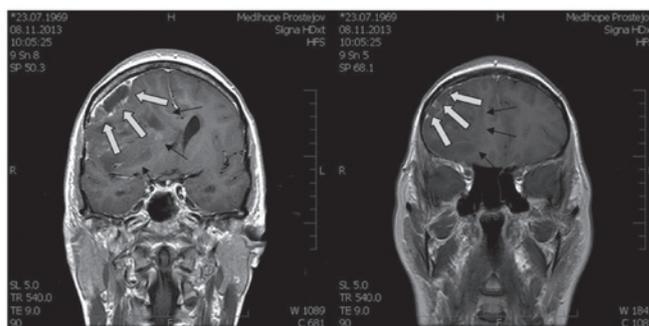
Preoperative magnetic resonance imaging coronal scan (high- and area low-grade areas).
